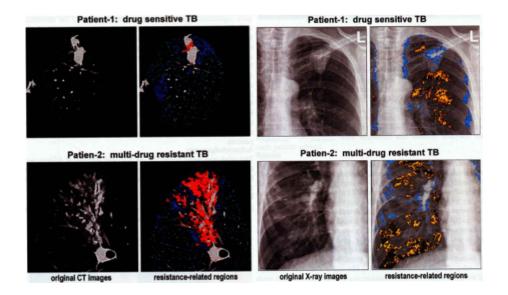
Lung CT&Xray images with drug sensitive and multi-drug resistant TB
